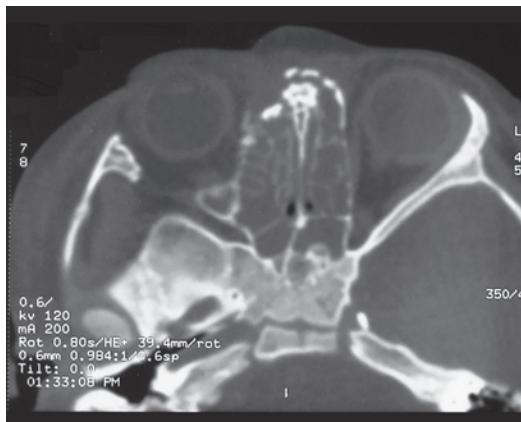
CT horizontal position of lacrimal fossa and bony nasolacrimal duct fracture in the right orbital medial wall
